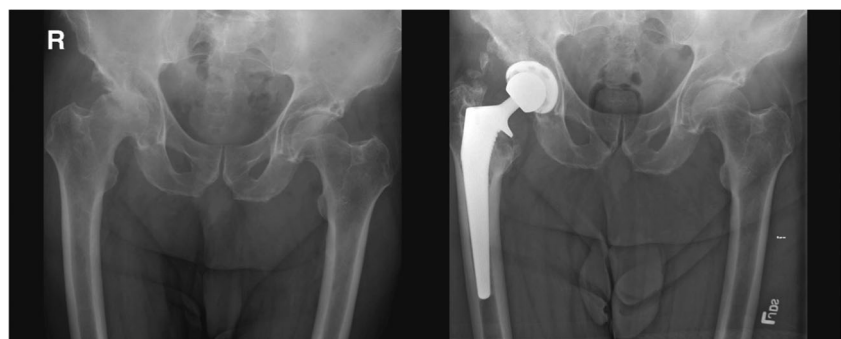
Grade 4 heterotopic ossification representative radiographs of a 61-year-old male who underwent posterior approach to total hip arthroplasty. Preoperative radiograph is seen on the *left*. He previously
